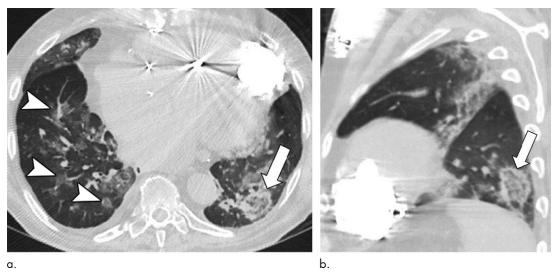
Images in a 72-year-old man with COVID-19 and a history of heart failure presenting with 10 days of cough. (a) Axial and (b) sagittal unenhanced thin-section chest CT images show peribronchial ground-glass opacities (arrowheads), as well as ground-glass opacity in left lower lobe with ring of denser consolidation (reverse halo sign) (arrow).
